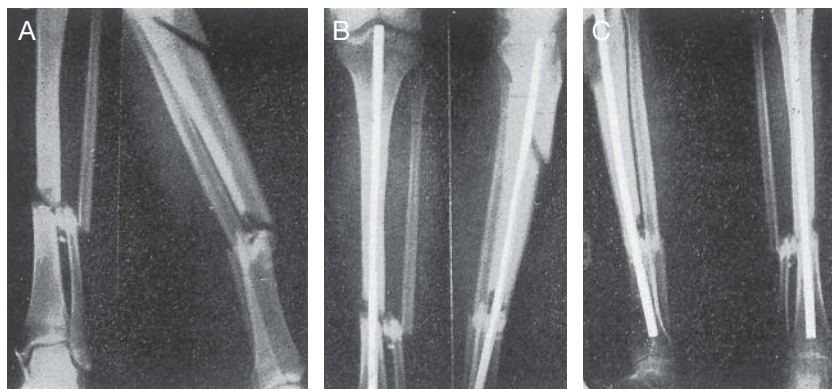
A.R.S. Open tibia and talar fracture with intermediate fragment and comminution in the lower fracture site. A: Preoperative x-rays. B: Radiographs at 1 month from the procedure. C: Final result at 6 months. Note that when healing occurred, a tibio-talar synostosis appeared through the free fragments.
